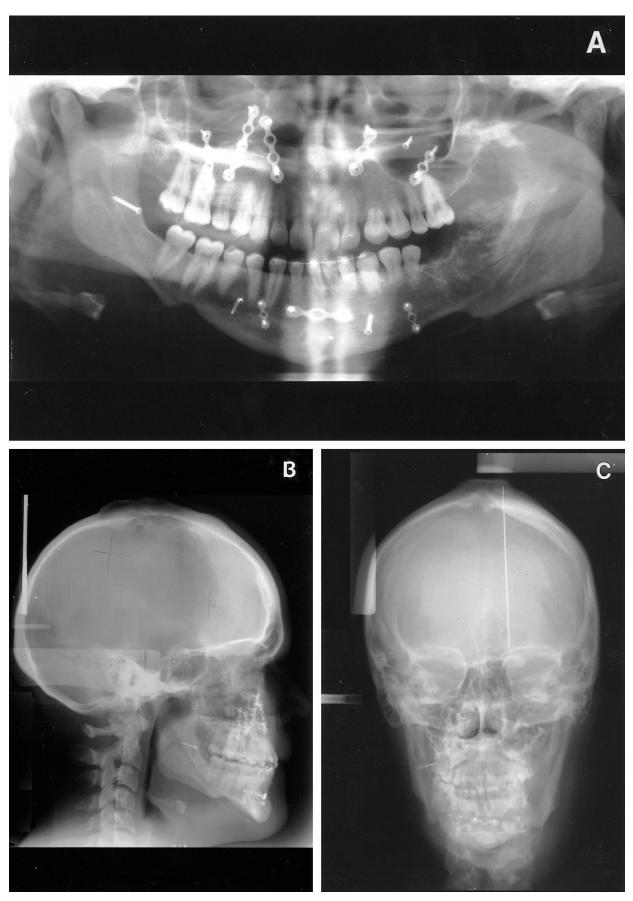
Panoramic (A), lateral (B), and frontal (C) cephalometric radiographs at age 20 years. Continued increased bone overgrowth can be observed on the posterior part of the left mandibular alveolar process. Note the relative osseous symmetry and leveled maxillary occlusal plane. This is in contrast to the obvious facial asymmetry from soft tissue hypertrophy (see Fig. 9).
